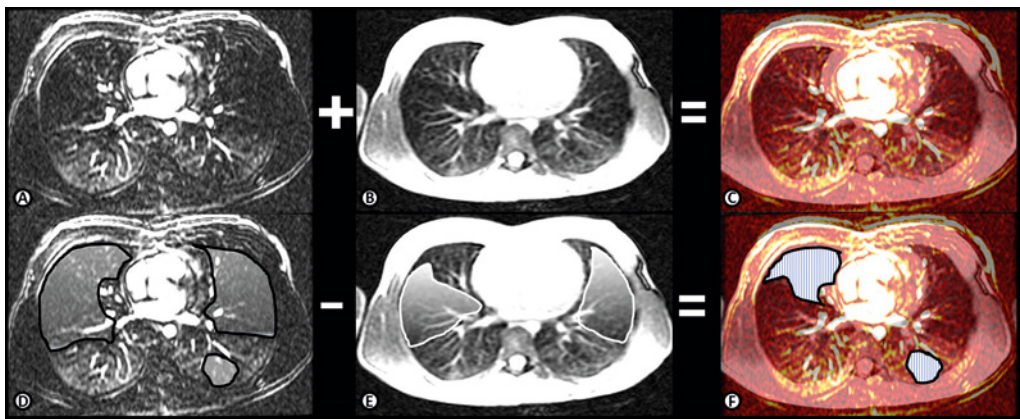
Comparison between MRI_{TA} and $CEMRI_{HP}$ by the second observer using the PROPER scoring system. (A and D) axial end-expiratory reformat 3D Spoiled Gradient Echo (SPGR) with TRICKS contrast-enhanced MRI (CEMRI); (B and E) end-expiratory axial 2D Steady-State Free Precession (SSFP) proton-MRI; and C and F) Fusion Image CEMRI overlaid on MRI. Note areas of hypoperfusion in both lungs in image D (black line areas) and areas of trapped air in image E (white line areas). When compared on fusion image F, hypoperfusion is larger than the trapped air areas (line pattern areas in F). Hence, for these lobes (right middle and left lower lobes) a score of 1 is given.
